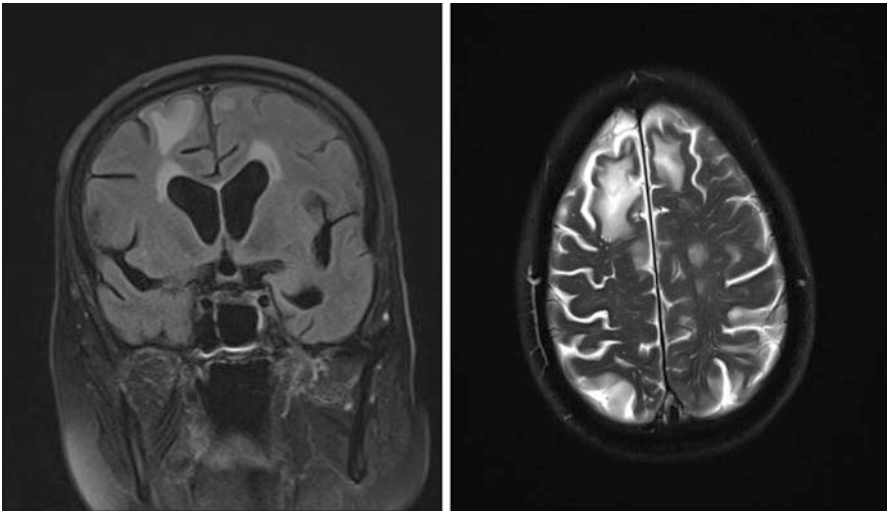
The MRI is apparently worse, there are diverse signal changes denoting dead brain tissue and the ventricles are larger
